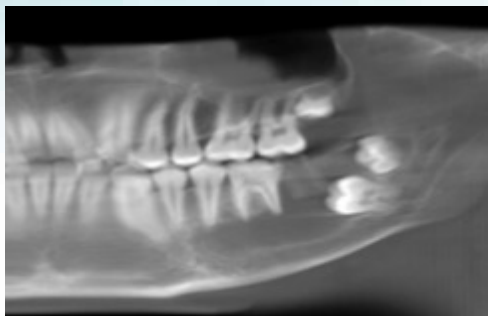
6th month follow-up OPG and CBCT
